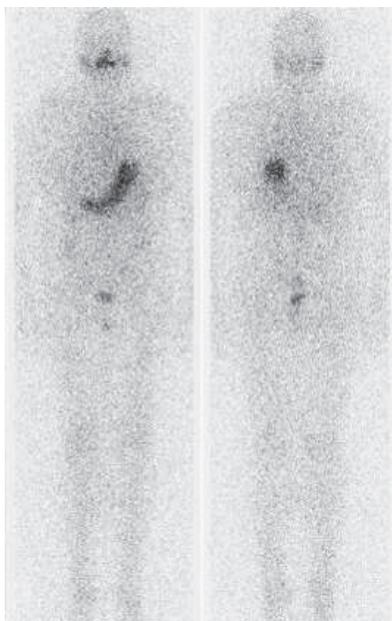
Diagnostic whole-body scintigraphy - normal finding
